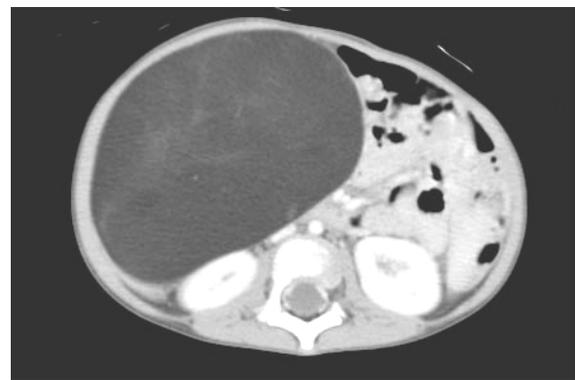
CT scan shows a large intraperitoneal fat density mass.
